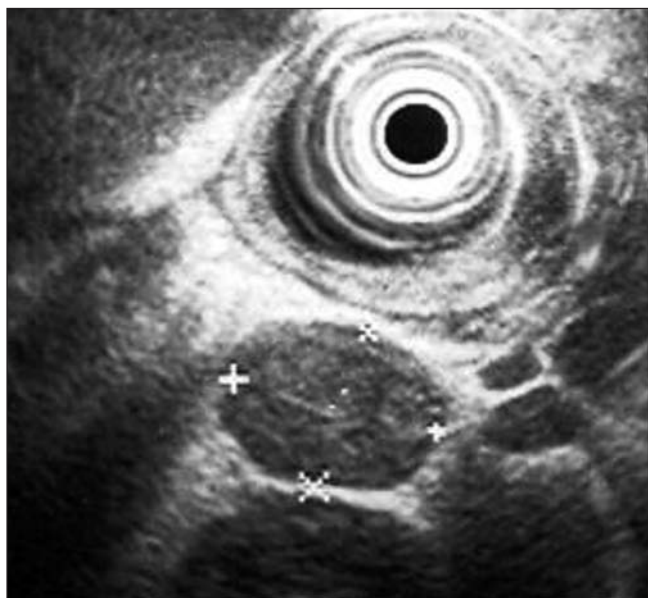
Perigastric adenopathy with a malignant aspect in ultrasound. Hypoecogenic, well defined, rounded, homogeneous and larger than 1 cm.
